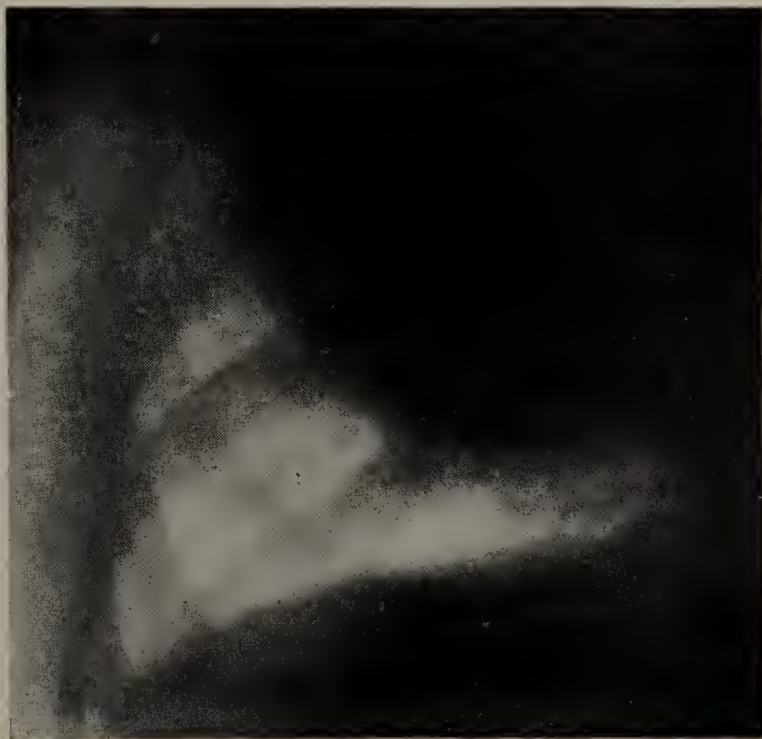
Daniel M. Radiograph taken with plate on front of chest and tube behind the back. The curved outline of the dark mass above the light area corresponds to the outline seen on the fluorescent screen (Fig. 192, page 336). Below the light area, which is crossed by the ribs on front and back of thorax, is seen a portion of the diaphragm. (About one-third size of original.)
